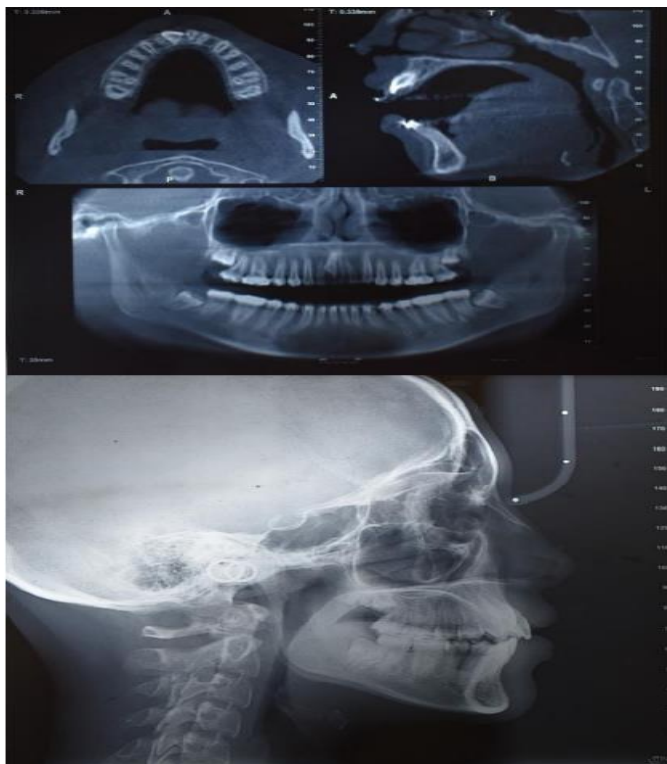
Pre-treatment Radiograph and CBCT.
